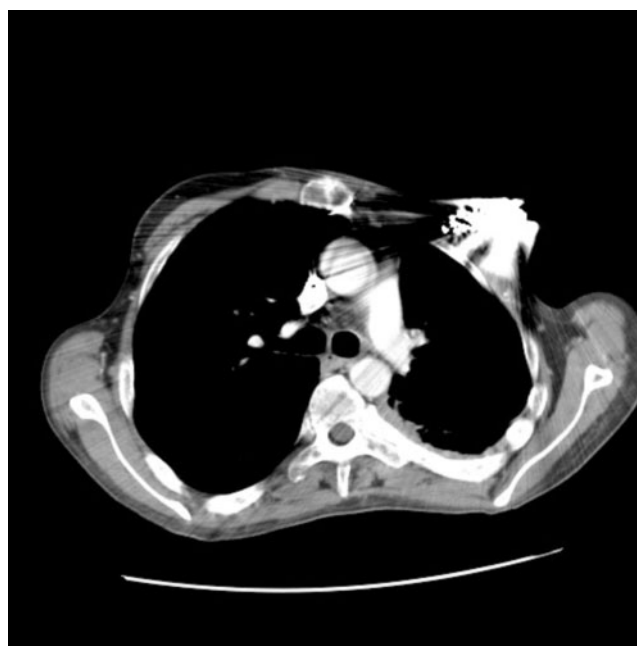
CT scan after Sandostatin (October 2008).
